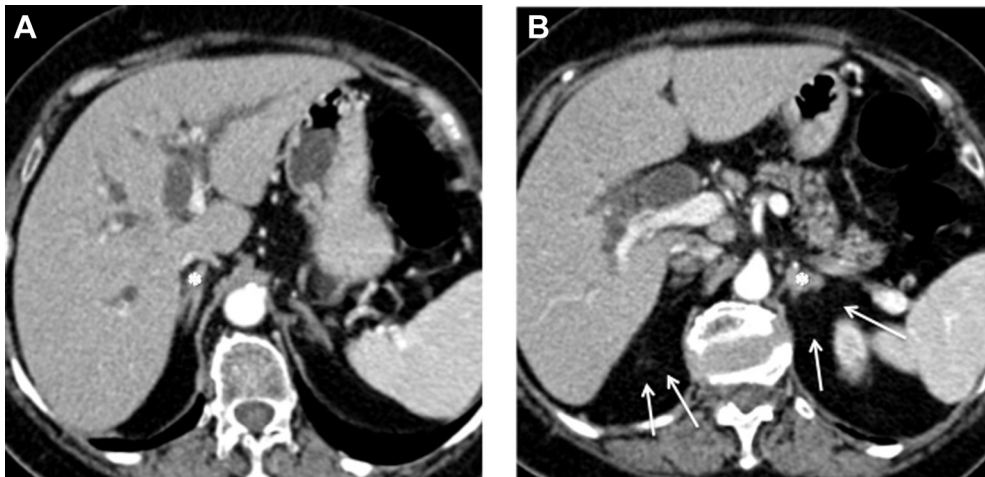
Computed tomography, axial image, portal phase showed bilateral (A: right; B: left) mild adrenal enlargement (stars) with surrounding fat stranding (arrows).
